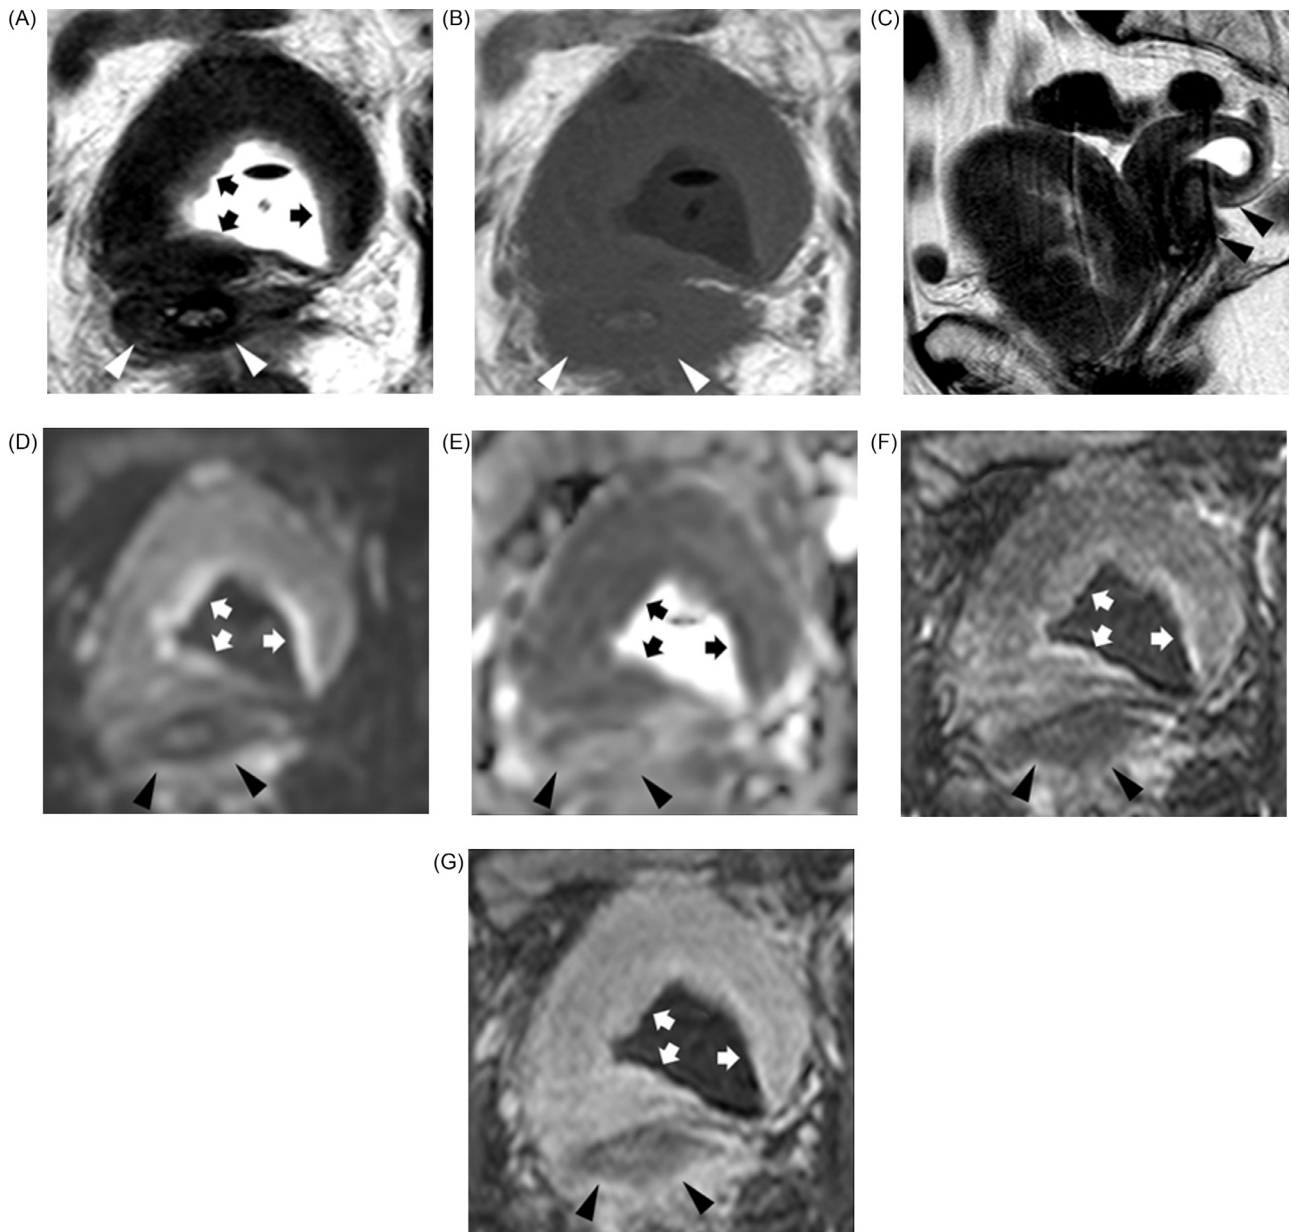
Magnetic resonance images in a patient with plasmacytoid urothelial carcinoma. On the axial T2WI (A), the bladder shows diffuse wall thickening. The inner layer of the thickened bladder wall (arrows) shows a high signal intensity, and the outer layer shows a low signal intensity. On the axial T1WI (B), the inner and outer layers of the thickened bladder wall show low signal intensity. On the sagittal T2WI (C), the thickened bladder wall appears in contact with the uterus. Compared to the outer layer, the inner layer (arrows) shows significant hyperintensity on DWI with a b-value of 1000 s/mm^2 (D). The inner and outer layers show low ADC values (arrows) on the ADC map. They were $0.86 \times 10^{-3} \text{ mm}^2/\text{s}$ and $0.89 \times 10^{-3} \text{ mm}^2/\text{s}$, respectively (E). DCE fat-saturated T1-weighted images acquired before and at 30, 70, and 150 s after the injection of gadoxetic acid. Axial subtraction (post-contrast scan delay of 30 s minus pre-contrast scan) (F) shows marked enhancement of the inner layer (arrows) and mild enhancement of the outer layer. Axial subtraction (post-contrast scan delay of 150 s minus pre-contrast scan) (G) shows strong enhancement of the inner layer (arrows) and moderate enhancement of the outer layer. *arrowheads: uterus.
